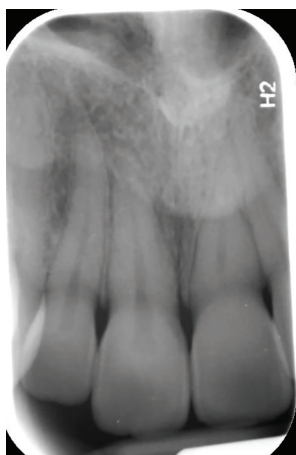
Peri-apical radiographs should include the clinical crown, entire root length, peri-apical region of the imaged tooth and adjacent periodontium.
